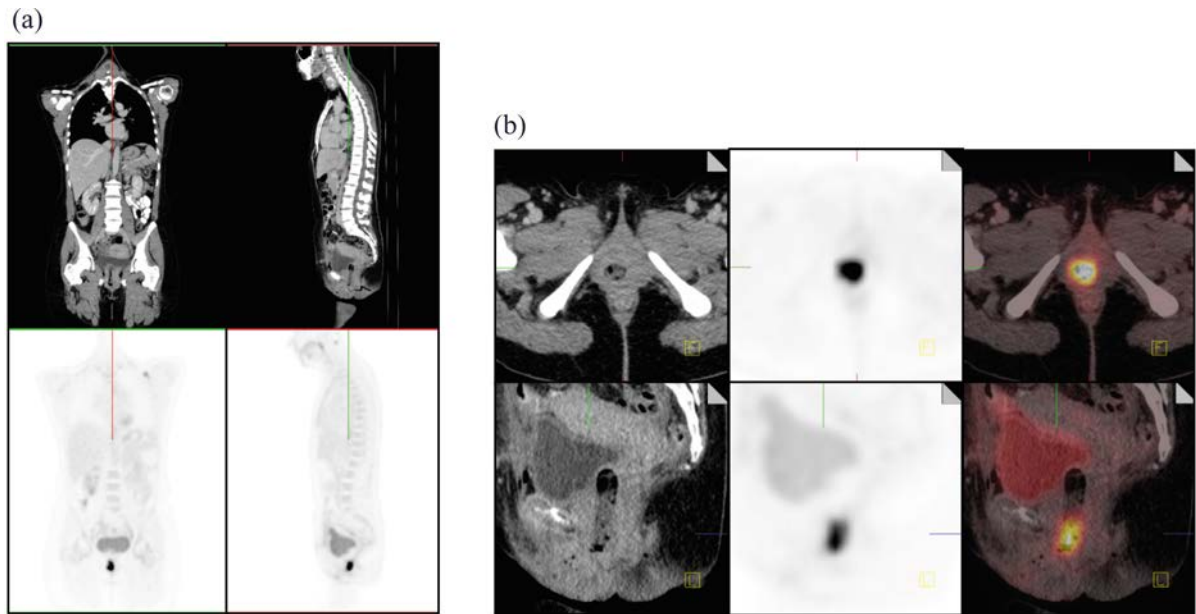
(a) Coronal and sagittal CT and PET images demonstrating a hot spot in the lower pelvis; (b) a zoom in view of the spot on CT, PET and fused PET/CT localizes the finding of tracer uptake to an internal absorber.
